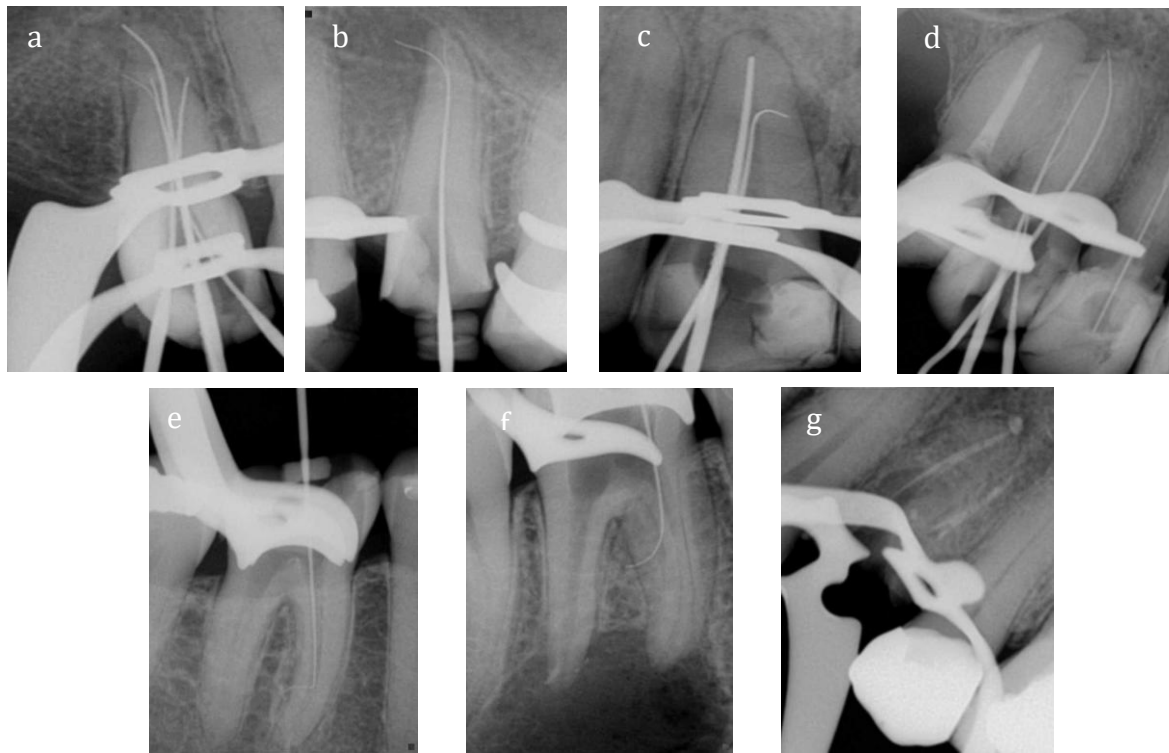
Periapical radiograph after mechanical access of the accessory canal. (a) case 1; (b) case 2; (c) case 3; (d) case 4; (e) case 5; (f) case 6; (g) case 7.
